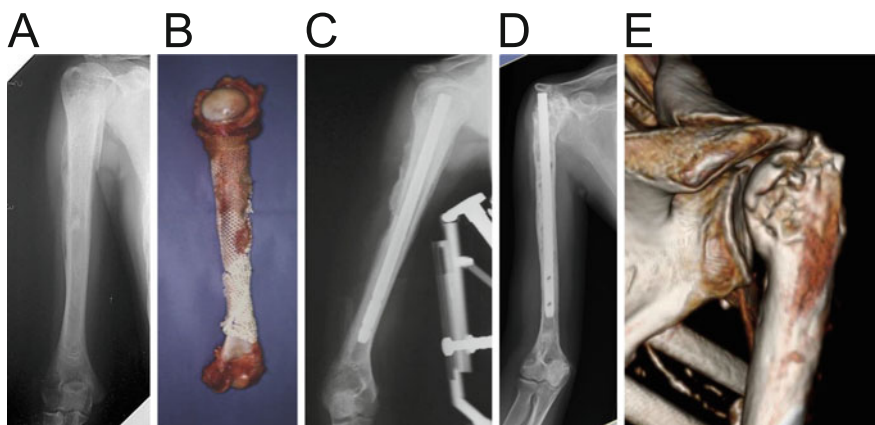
Collapse of humeral head in an osteoarticular graft of the whole humerus. (a) Pre-operation XP. (b) Implanted irradiated bone. (c) Post-operation XP. (d) XP at 18 years later. Humeral head is collapsed but the irradiated distal humerus is still healthy. (e) 3D-CT shows that the articular surface of the glenohumeral joint is still preserved
